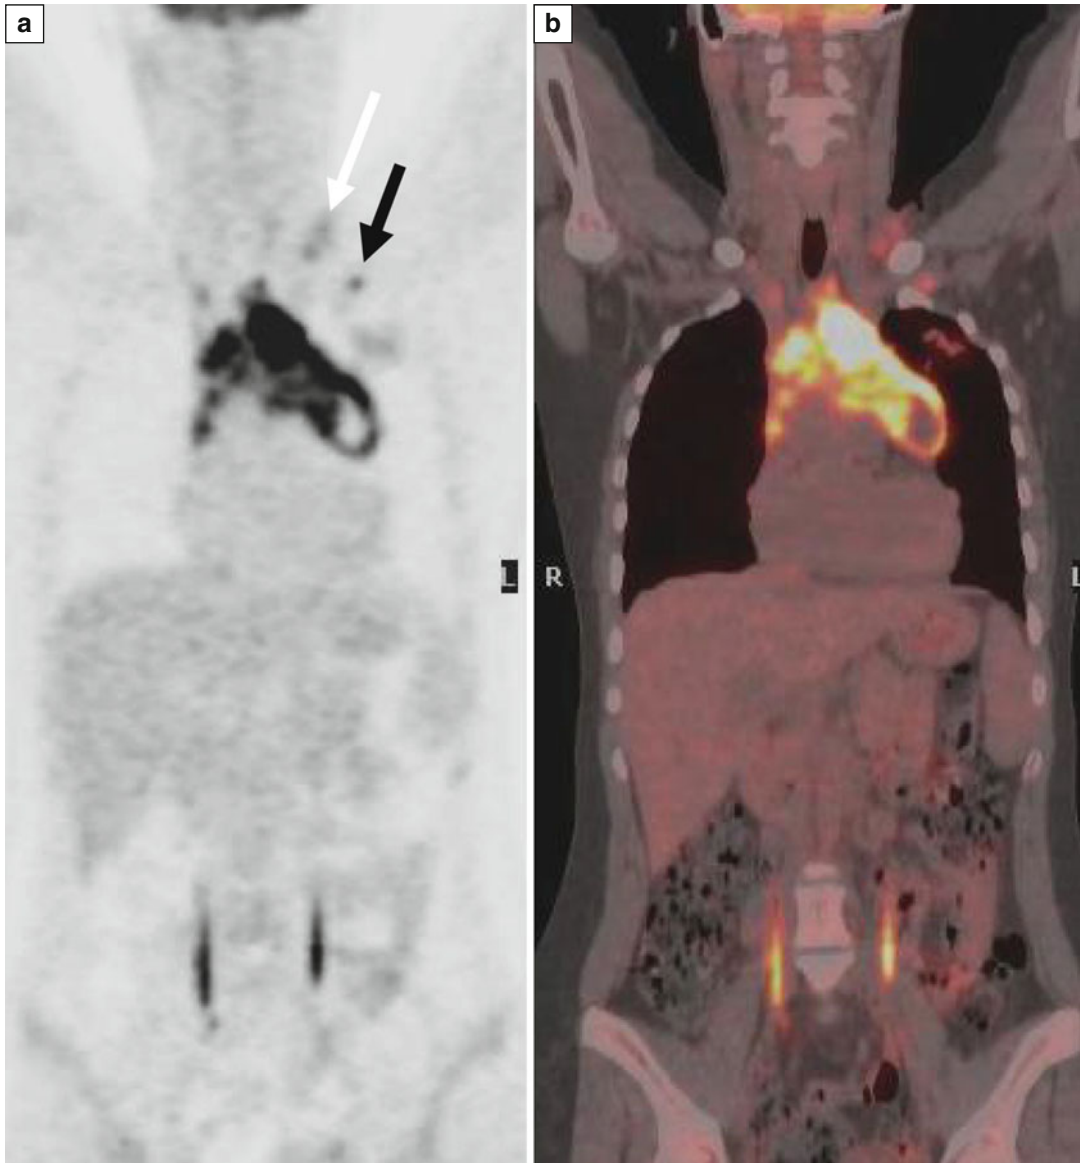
(a, b) PET and fused PET/CT – initial staging: Mediastinal hypermetabolic mass, *left* supraclavicular lymphadenopathy (*white arrow*) and further revealed other sites of mediastinal and *left* axillary lymphadenopathy (*black arrow*)
